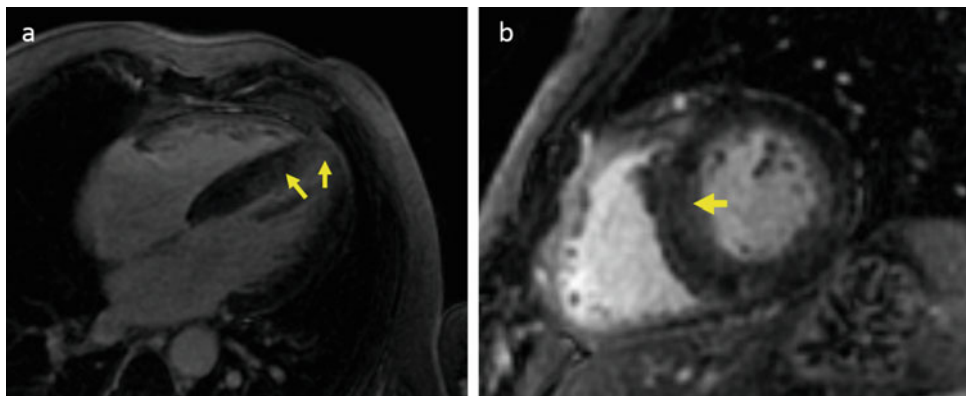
Cardiac MRI showing asymmetric septal hypertrophy with late gadolinium in midmyocardial distribution affecting the septum and the apical tip. a Four-chamber view of the left ventricle. b short axis of the left ventricle
